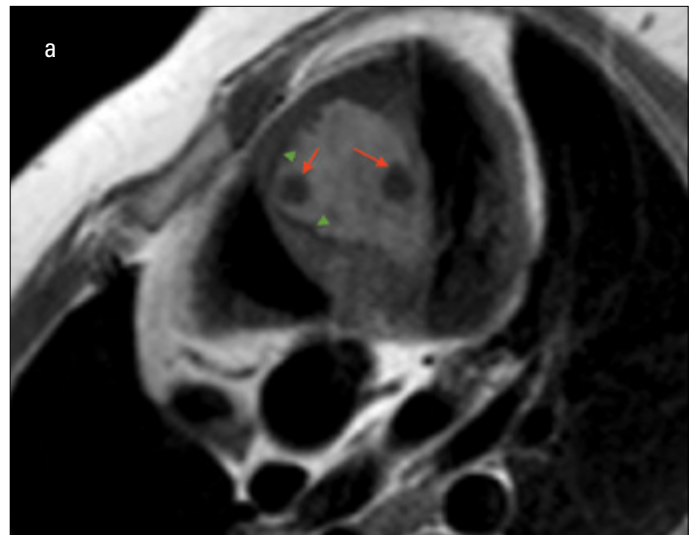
a, b. Cardiac MRI showed a cystic mass which was located in the interventricular septum and 5X4X3 cm in size. It was showing peripheral contrast enhancement and a few pieces of cystic spaces that had the largest 1.5 cm in size which was compatible with hydatid cysts (Red arrows pointing cystic spaces in cystic mass, green arrow heads pointing peripheral contrast enhancement)
